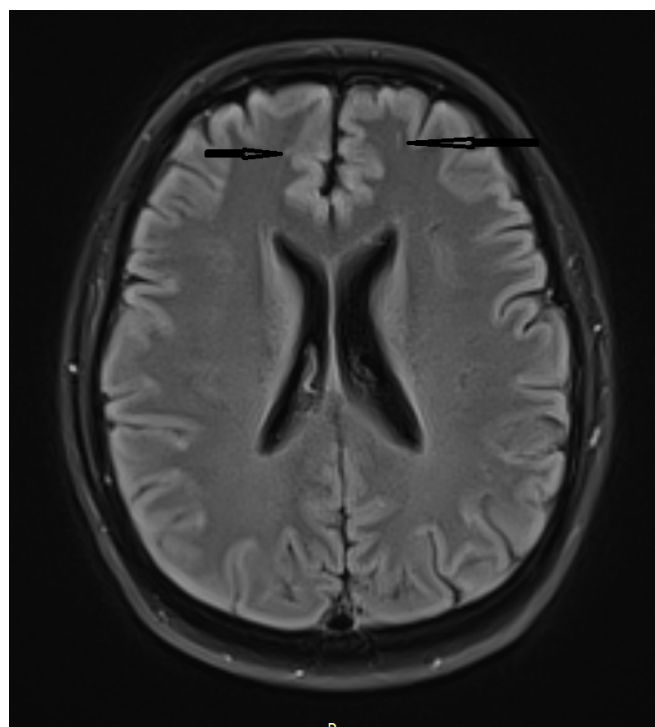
Axial T2-weighted MRI. In the subcortical white matter of the frontal lobes is determined by the presence of areas of increased MR signal (indicated arrow).
